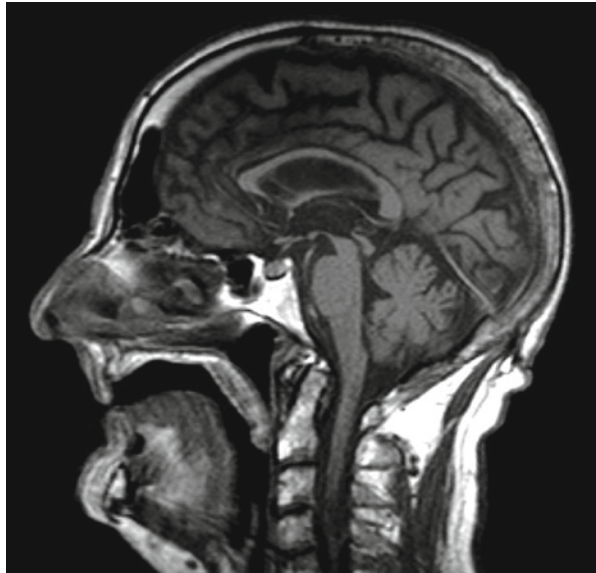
Sagittal T1-MRI through the brainstem showing volume loss in the midbrain with relative preservation of the pons in PSP. The upper convexity of the midbrain is lost giving a “hummingbird” appearance
